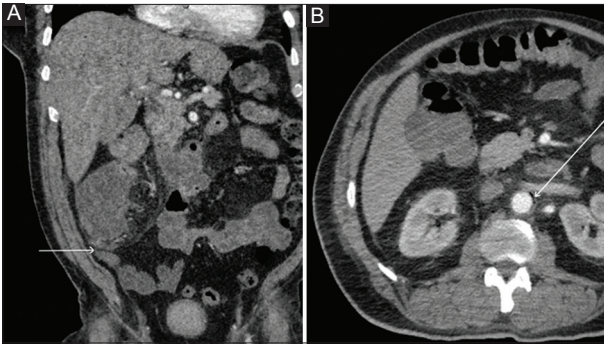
White arrows point to the right colon mass (A) and periaortic gas (B) seen on computed tomography scan
